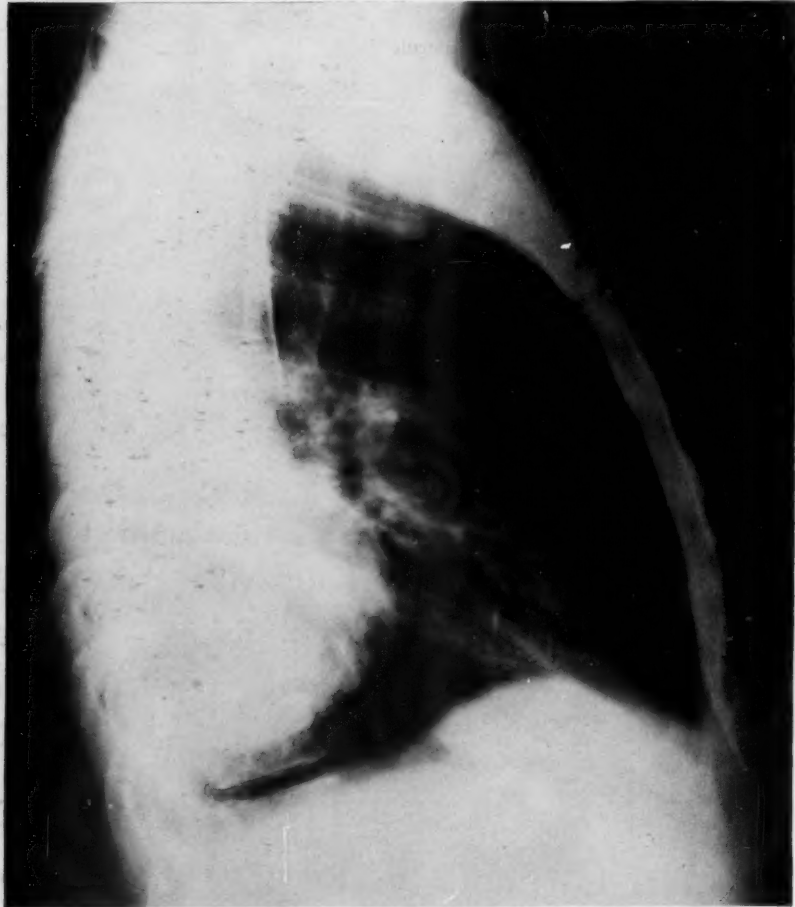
Case 12, Table I: Right lateral roentgenogram demonstrating that both empyemata lie posteriorly. The left empyema, with fluid level, is obscured by the right.
